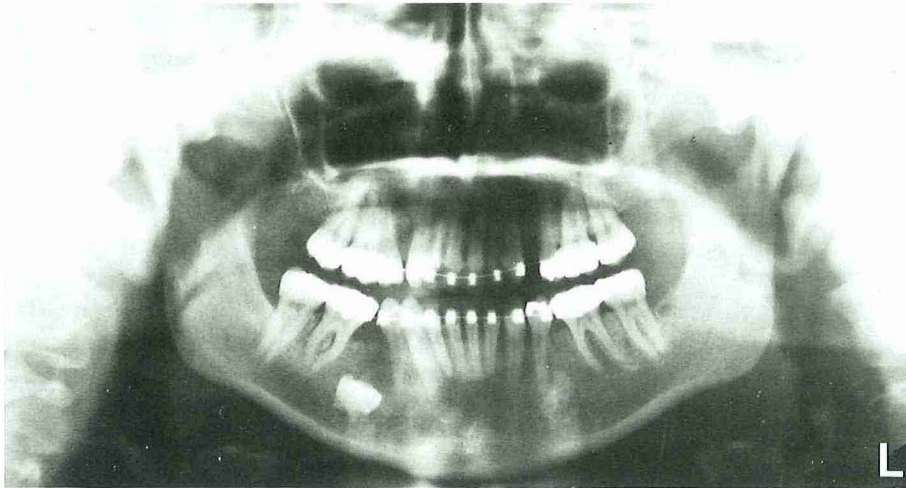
Orthopantomogram of a 23-year-old woman showing an unerupted mandibular deciduous molar on the right side.
